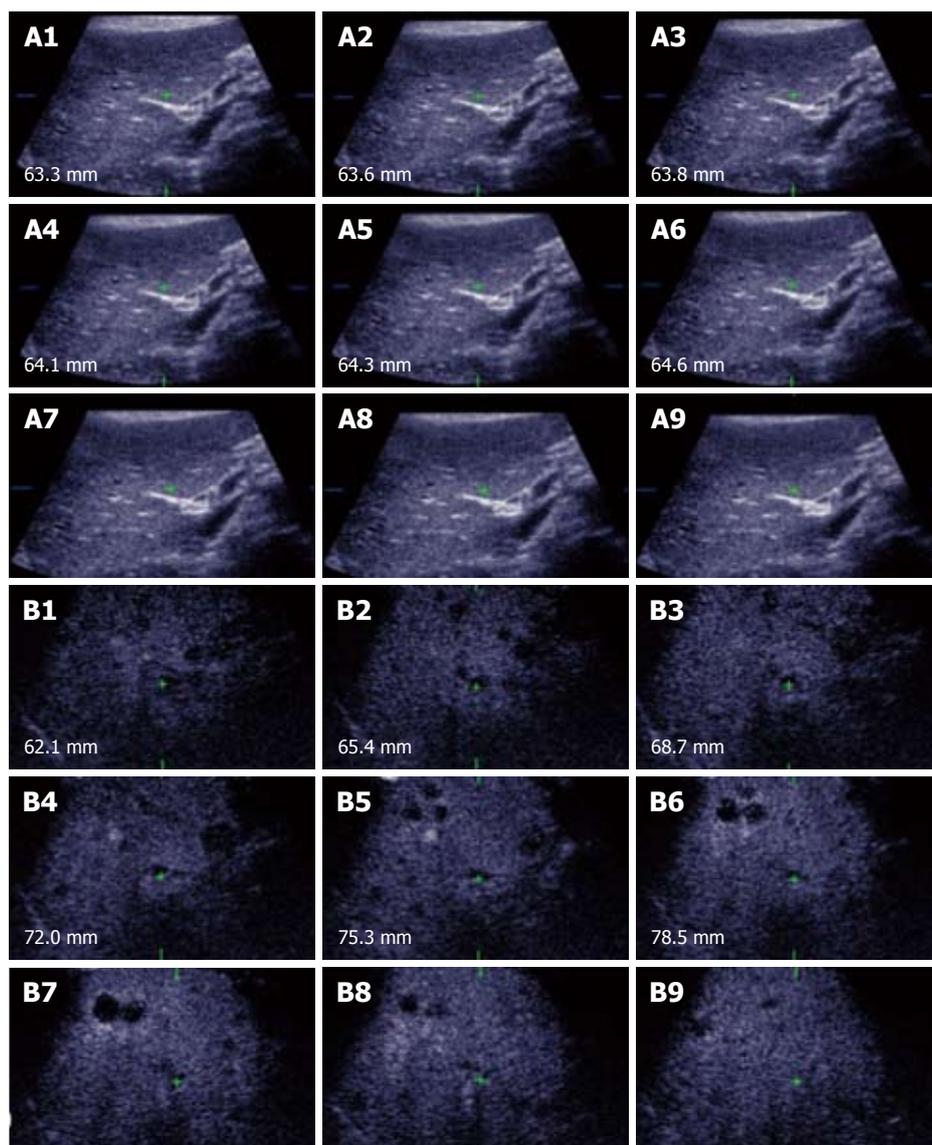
Unenhanced ultrasound and contrast enhanced 3D US. A: Unenhanced Fundamental mode ultrasound showing apparently normal liver; B: Contrast enhanced 3D US displayed as axial scans showing numerous occult metastases appearing as filling defects in the late phase.
